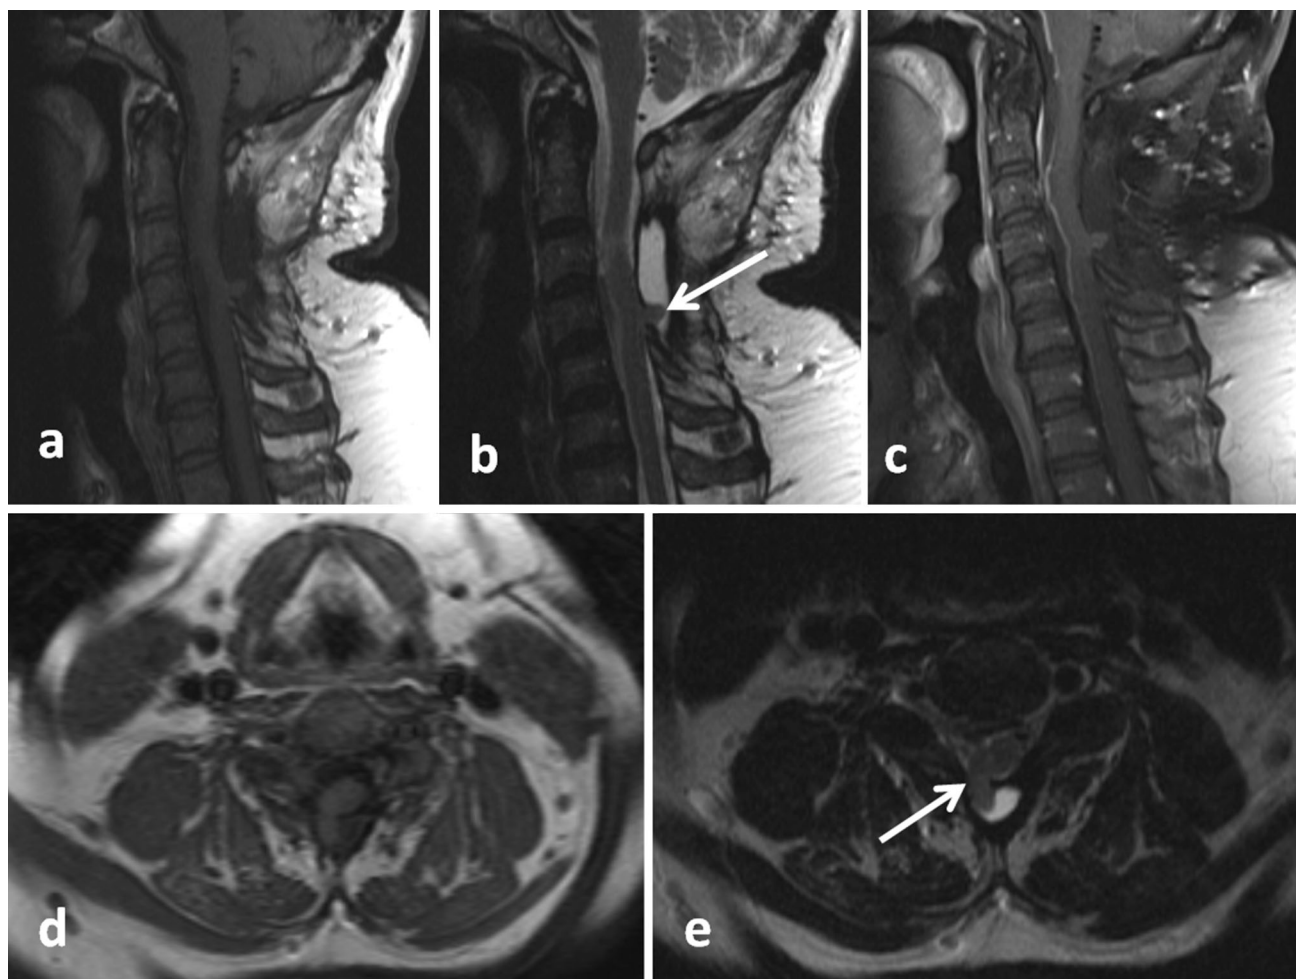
Pre-operative MRI images at the second presentation. a T₁ weighted image of sagittal section of the cervical spine showing a spinal cord herniation at the C4 level along the dorsal aspect. b The T₂ weighted sagittal section image shows a pseudomeningocele sac with cord herniation along the dorsal aspect (*arrow*). c The post
